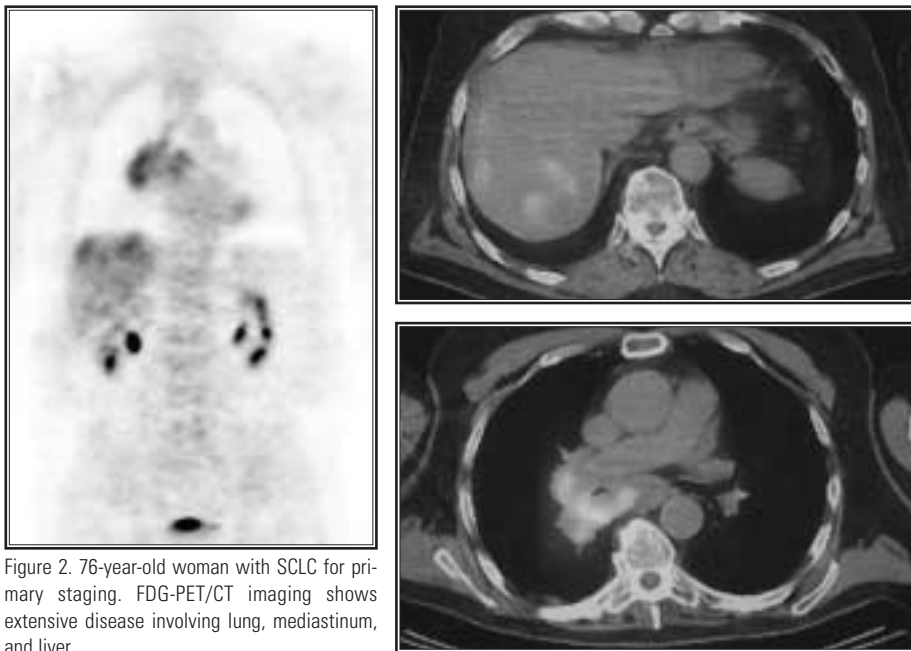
76-year-old woman with SCLC for primary staging. FDG-PET/CT imaging shows extensive disease involving lung, mediastinum, and liver.
